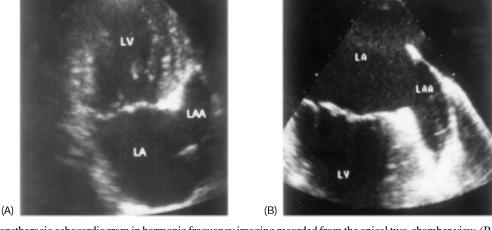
(A) Transthoracic echocardiogram in harmonic frequency imaging recorded from the apical two-chamber view. (B) Transesophageal echocardiogram of the same patient recorded from the longitudinal two-chamber view. LA = left atrium, LAA = left atrial appendage, LV = left ventricle.
